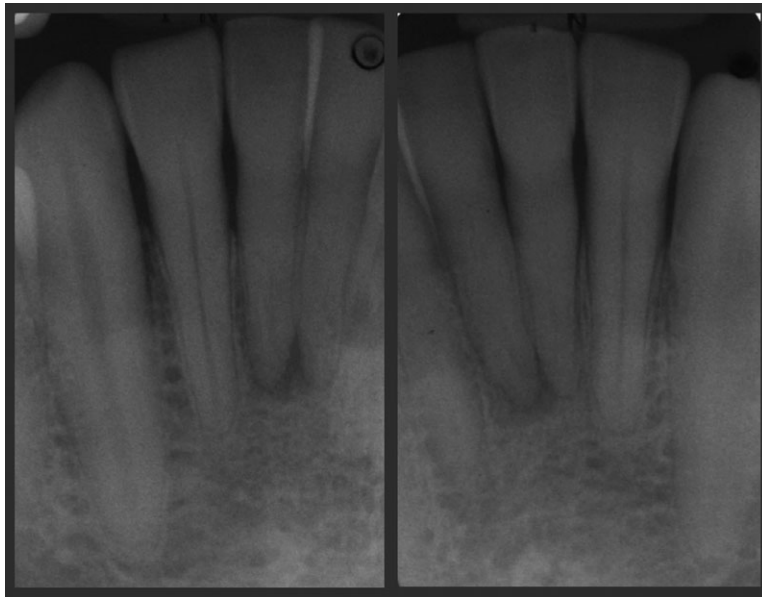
Radiographic images of teeth 31 and 41.
